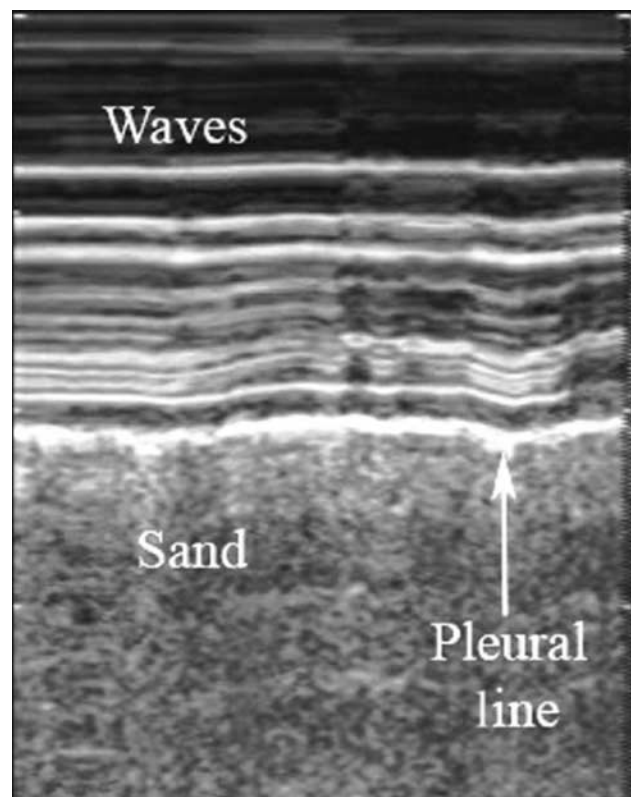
Seashore sign in M-mode. The pleural line divides the image in half. The motionless portion above the image creates horizontal lines (waves). The moving lung below creates a granular pattern (sand). This image is licensed under [CC BY-NC-SA 3.0](https://creativecommons.org/licenses/by-nc-sa/3.0/), and reproduced from Husain LF, Hagopian L, Wayman D, Baker WE & Carmody KA 2012 Sonographic diagnosis of pneumothorax. *Journal of Emergencies, Trauma, and Shock* 5 76–81. doi:10.4103/0974-2700.93116
